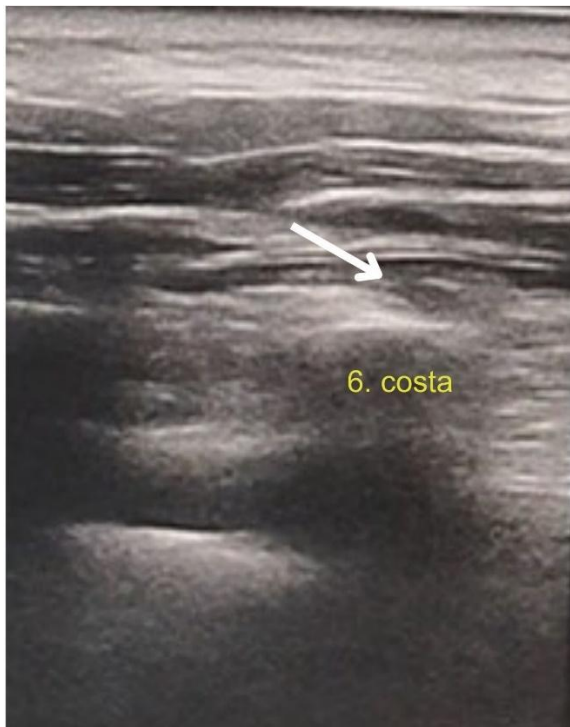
With the patient in the supine position, the ultrasound probe is placed in the sagittal plane at the level of the sixth rib between the midclavicular and anterior axillary lines. A paramedian sagittal oblique view is obtained with a short-axis view of the ribs approximately 1 to 2 cm medial to the anterior axillary line. The following structures were identified from superficial to deep: subcutaneous tissue, external oblique muscle, intercostal muscles between the ribs, pleura and lung. The skin entry point for injection is cranial to the level of the sixth rib, just medial to the anterior axillary line. The needle tip is advanced superomedially to inferolaterally along the external oblique muscle and finally reaches the tissue between the external oblique and intercostal muscles at the caudal end of the sixth rib and between the sixth and seventh ribs. Local anesthetic is injected into the area described and marked with a white arrow in the figure
